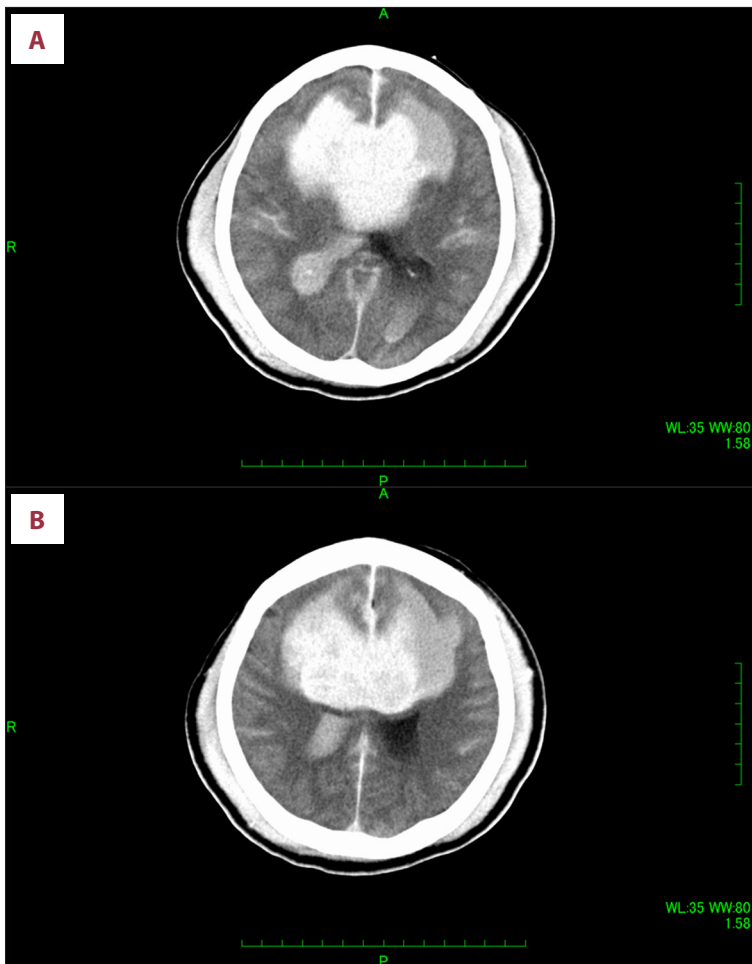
(A, B) Subsequent head CT scan showed massive intracranial hemorrhage with penetration to the ventricle.
